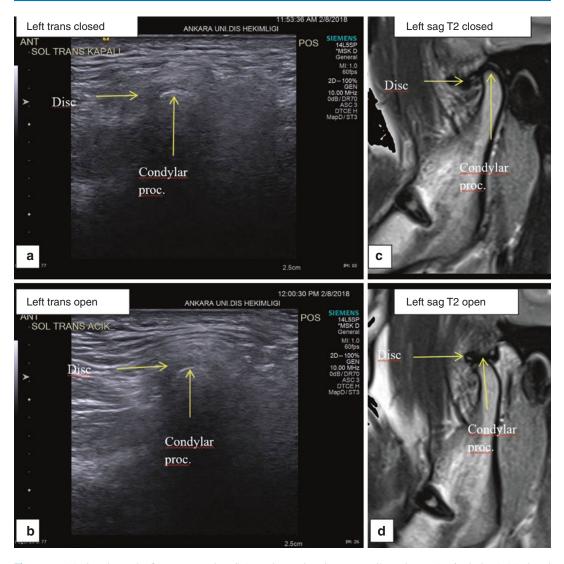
(a) closed mouth; (b) open mouth, US (transducer placed transversally and MRI (sagittal plane) (c) closed mouth; (d) open mouth images showing left TMJ with disc displacement with reduction
